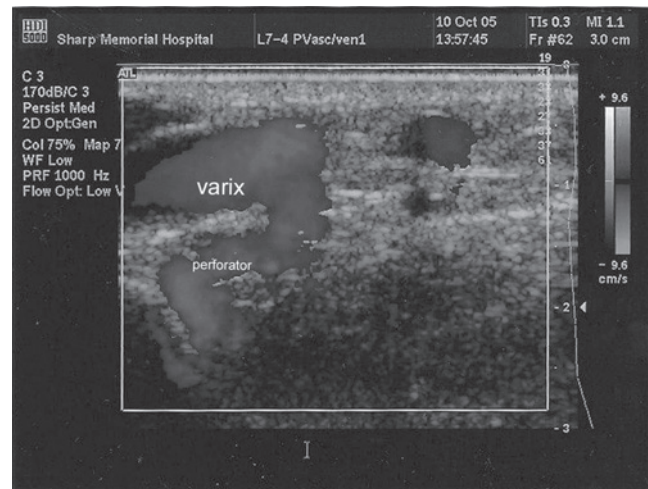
This reproduction of an ultrasound scan shows a perforating vein penetrating the deep fascia and refluxing into a nonsaphenous varix. It is calf muscle contraction that provides the pressure that is transmitted through a failed valve and elongates and dilates the superficial vein thus converting it into a varix.
